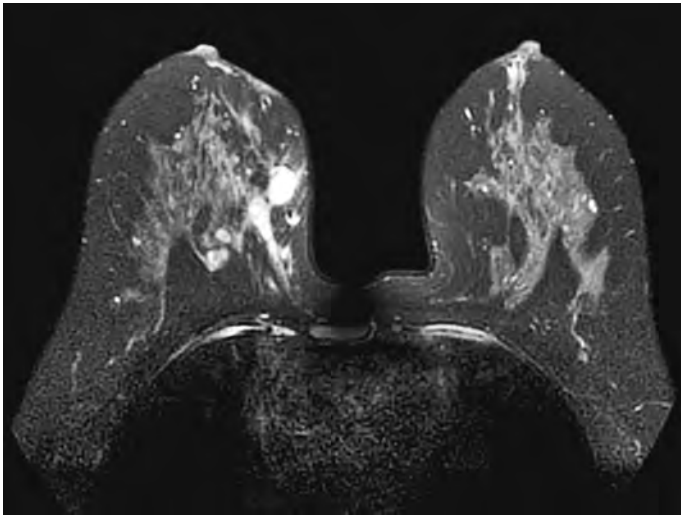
In breast MRI, on axial fat-suppressed T2W images, an oval-shaped, well-circumscribed cystic lesion in the middle of the right breast can be observed
